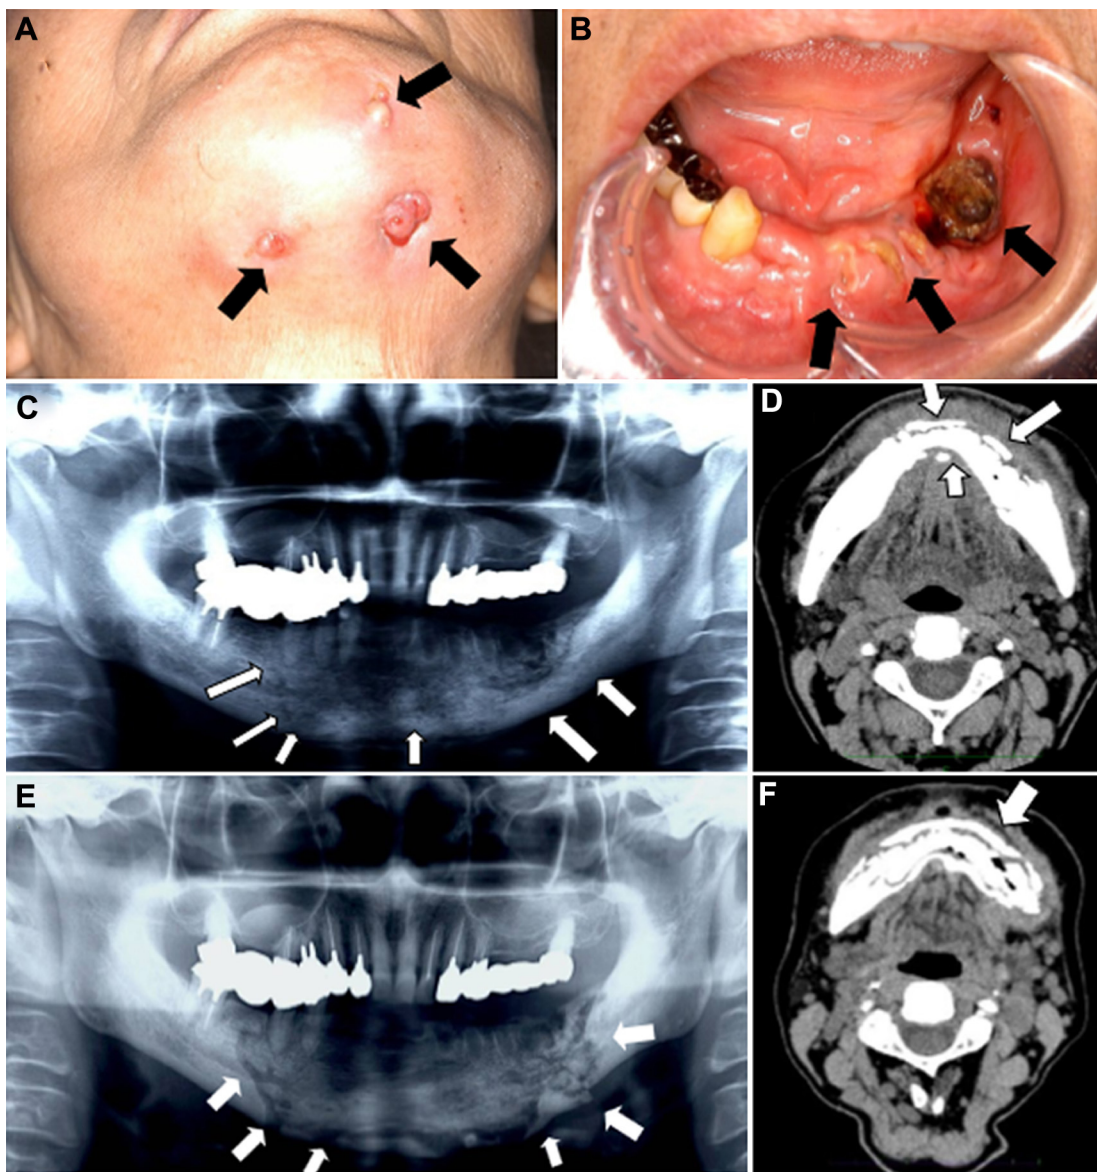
Bisphosphonate-related osteonecrosis of the jaw (BRONJ) in a 77-year-old woman. (A) Extraoral view; (B) intraoral view; (C and D) radiographic and CT images at the initial visit; and (E and F) radiographic and CT images at 16 months after conservative treatments. The patient had fistulas in the mental region of the skin (A). In her left molar region of the mandible, the exposed necrotic bone is located (B). Panoramic radiograph reveals bone destruction over a wide region of the mandible (C). A CT-scan identified the appearance of the necrotic cortical bone in the left and anterior mandible (D). Panoramic radiograph reveals an advanced bone destruction and a pathological fracture in the left mandible (E). A CT-scan confirms the presence of an advanced disease (F).
